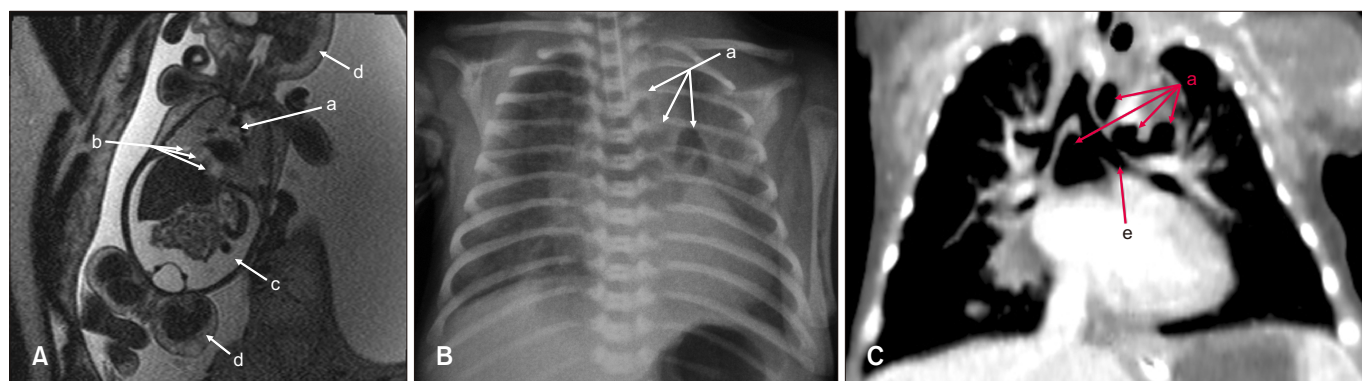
(A) The fetal magnetic resonance imaging showing hydropic fetus. (B) Neonatal chest X-ray showing air-fluid level in the mediastinal cystic lesion. (C) Thoracic computed tomography scan. a: multicystic mediastinal mass, b: intrapulmonary subpleural lesions, c: ascites, d: subcutaneous oedema, e: left main bronchus.
